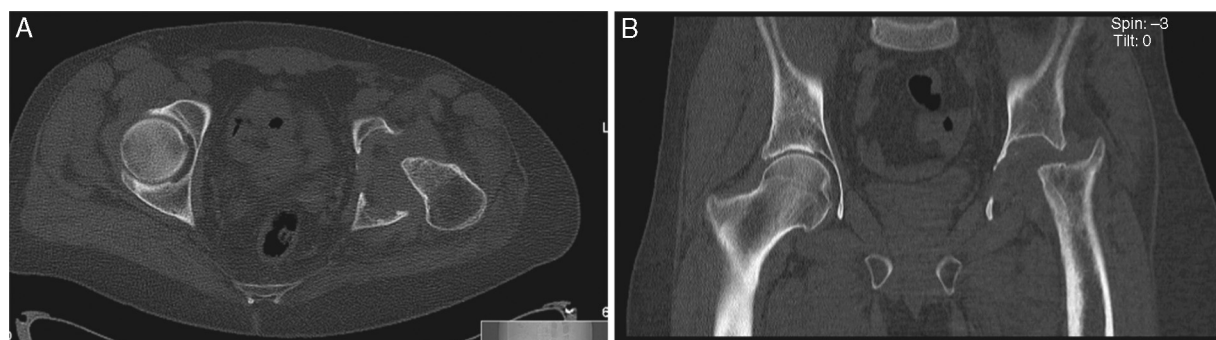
(A) CT scan of the pelvis (axial slice) and (B) CT scan of the pelvis (coronal slice).
